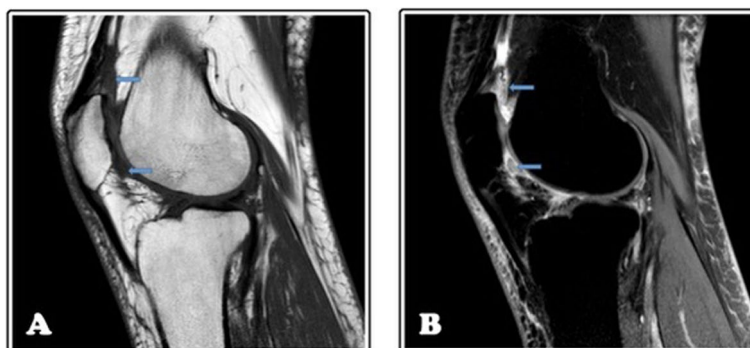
MRI after 4 months of treatment with tocilizumab. Sagittal T1-w FSE image (A) and FS PD-w FSE image (B). In the joint recesses, a thickening of the synovium is identified with a significant decrease in the size and number of amyloid deposits. In the superior Hoffa's and suprapatellar recesses, a nodule isointense to the muscle persists on T1-w FSE and FS PD-w FSE (arrows). Joint effusion is also found
